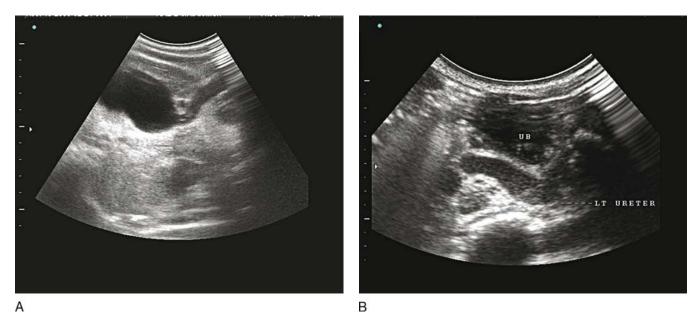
An ultrasound scan shows a dilated upper moiety and its dilated ureter up to the urinary bladder (UB)
